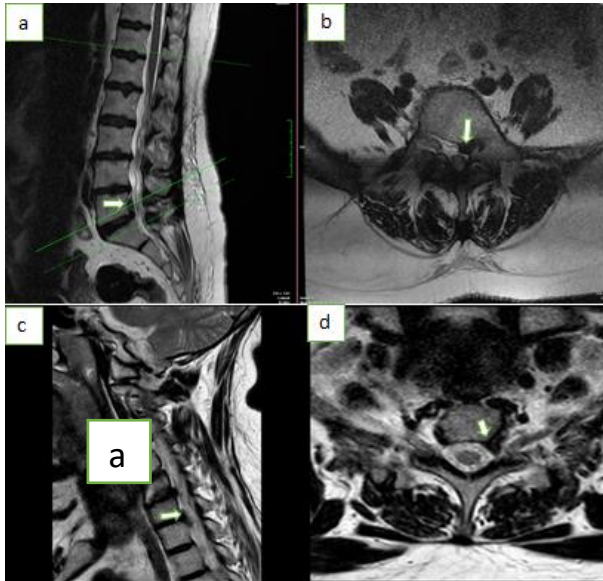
(a) Sagittal T2-weighted lumbar MRI showing an upwardly extruded lumbar disc herniation (*white arrow*), (b) axial T2-weighted lumbar MRI with a disc herniation compressing the left S1 nerve root (*white arrow*), (c) sagittal T2-weighted cervical MRI revealing an inferiorly migrated cervical disc herniation (*white arrow*), and (d) axial T2-weighted cervical MRI demonstrating a disc herniation impinging on the left cervical nerve root (*white arrow*).
